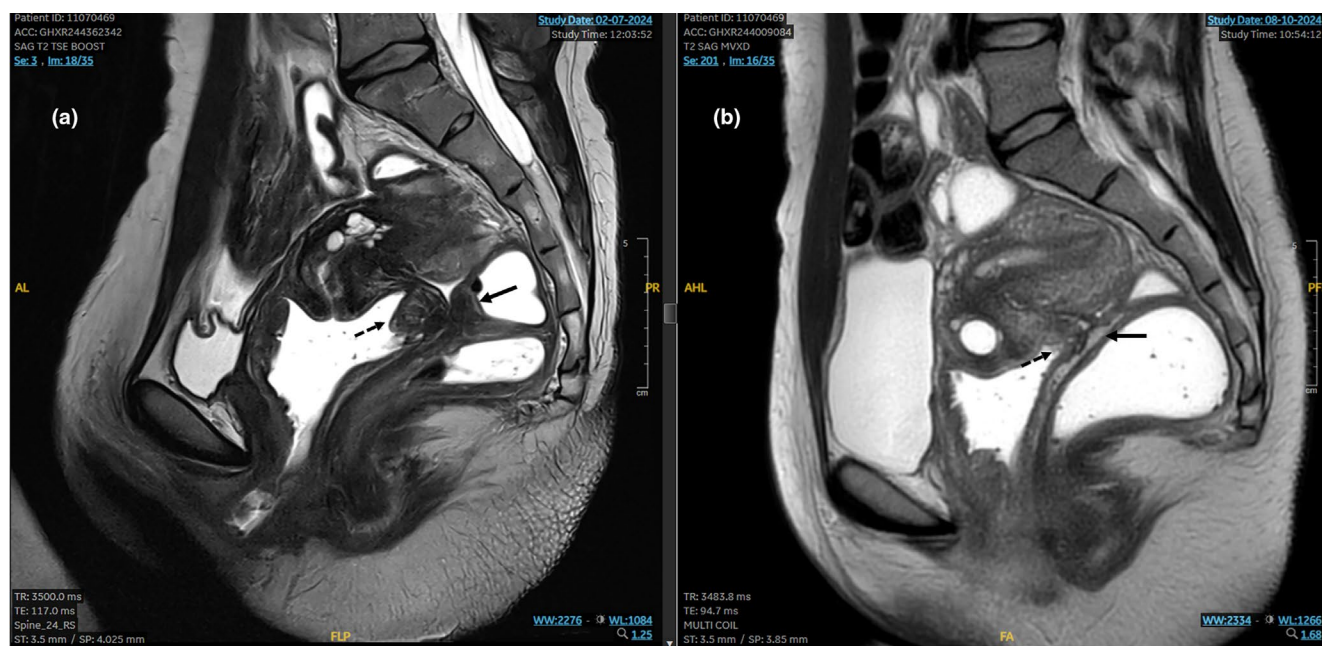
Pre- and 3 months post high-intensity focused ultrasound (HIFU) treatment magnetic resonance imaging (MRI) (T2 sequences) of a rectal endometriosis with vaginal involvement, No hormonal treatment. (a) Preoperatively. Sagittal T2-weighted MR image performed 15 days before HIFU treatment shows a consequent rectal lesion of the junction of the mid and high rectal anterior wall (arrow), with invasion of both the recto-vaginal septum and the posterior vaginal fornix (dotted arrow). (b) Three months after HIFU, no hormonal treatment since the treatment for a desire of pregnancy. Sagittal T2-weighted MR image shows a complete regression of both the rectal lesion and recto-vaginal septum involvement (arrow). An important decrease in size of the posterior vaginal cuff lesion (volume reduction >80%) (dotted arrow).
